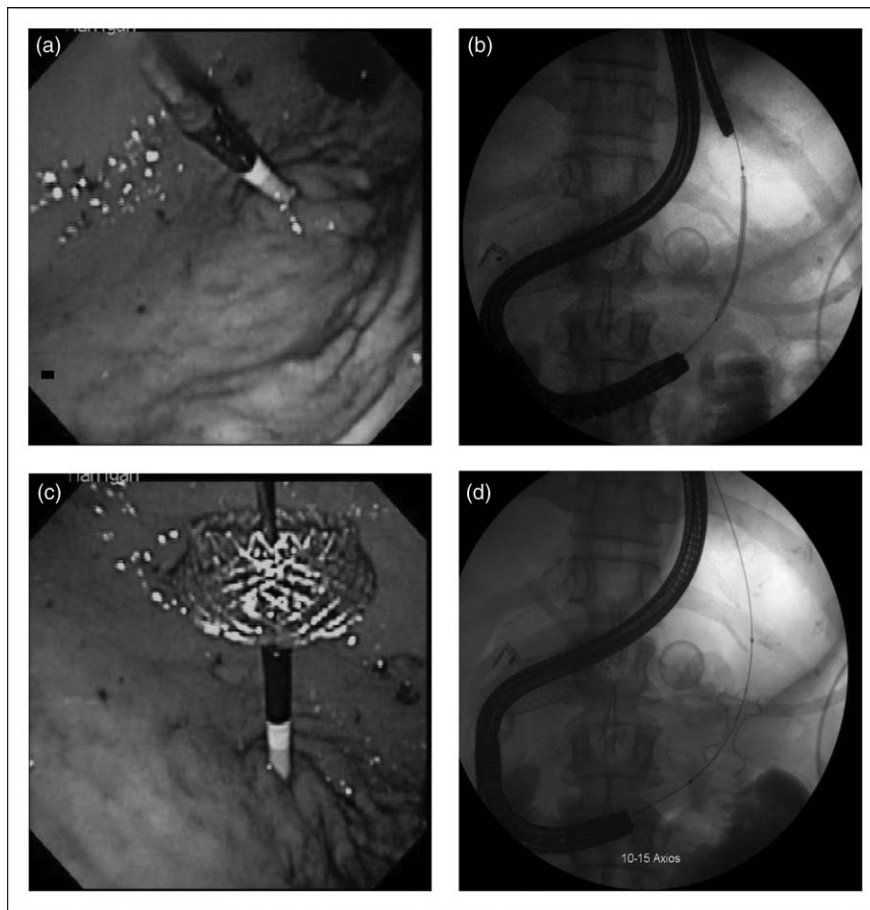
Retrograde EUS-GE: ‘Enterogastrostomy.’ (a), (b), (c) An endoscope can be advanced alongside the therapeutic gastroscopy to visualize the lumen-apposing metal stent opening in the stomach prior to (d) deployment of the duodenal flange. EUS-GE, endoscopic ultrasound-guided gastroenterostomy.
